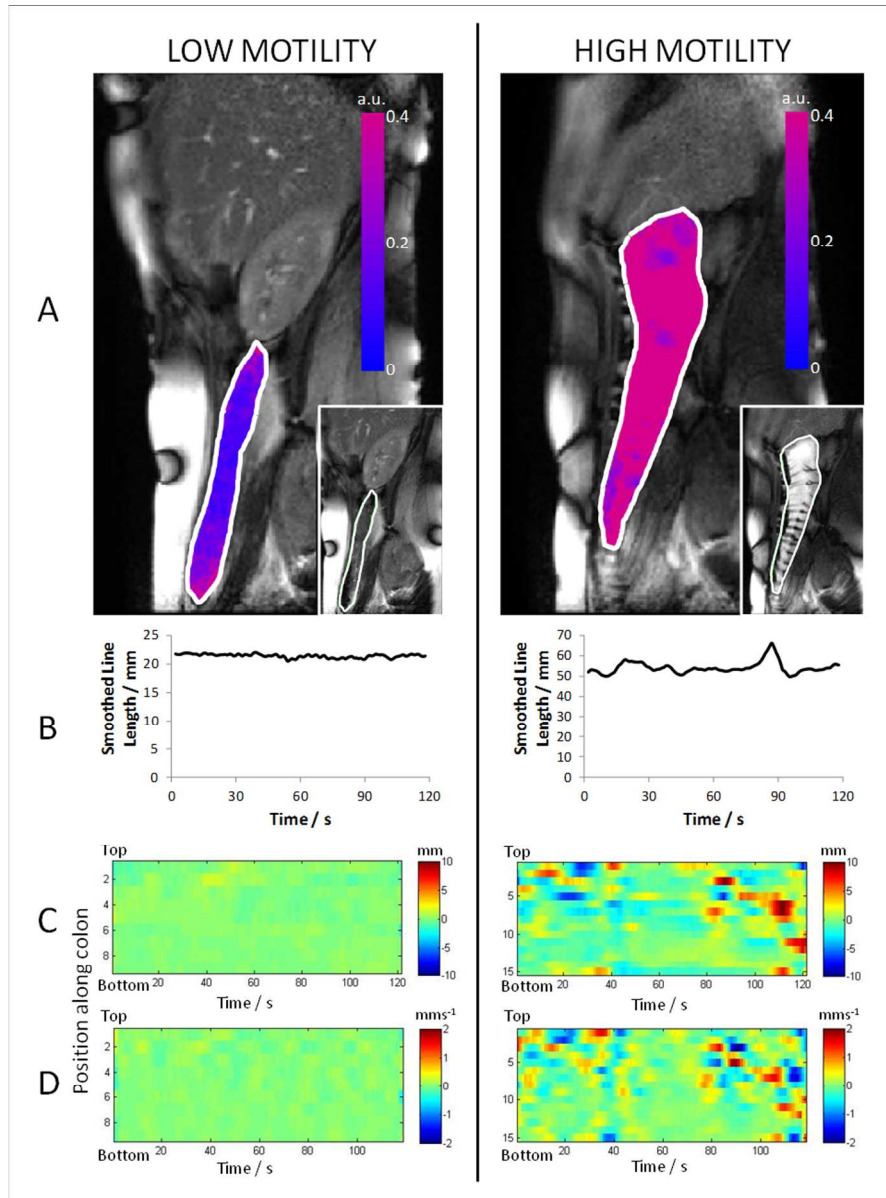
(A) Example images from cine MRI data showing overlay (red/blue) of standard deviation of Jacobian. Original data as insert. (B) Example single smoothed line length plot from mid AC. (C) Wall displacement motility plots from line analysis, colour bar indicates change in length of smoothed line length from mean. (D) Wall velocity motility plot, colour bar indicates change in consecutive line lengths after smoothing.
